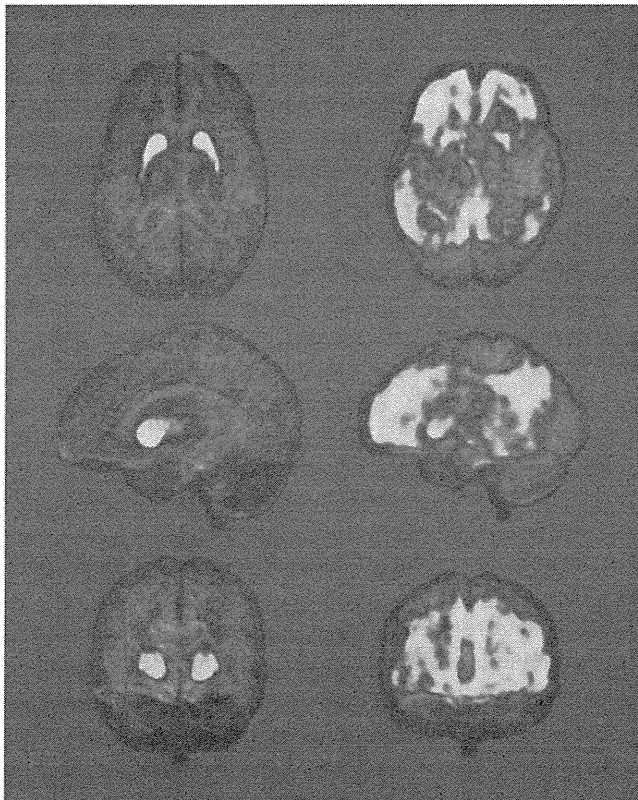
Comparison of the regional distribution of PiB retention in a presenilin-1 mutation carrier (*left*) and a sporadic case of AD (*right*). The MRI is shown in *gray* and PiB retention is overlaid in a hot metal scale on transaxial (*top*), sagittal (*middle*), and coronal images (*bottom*)
